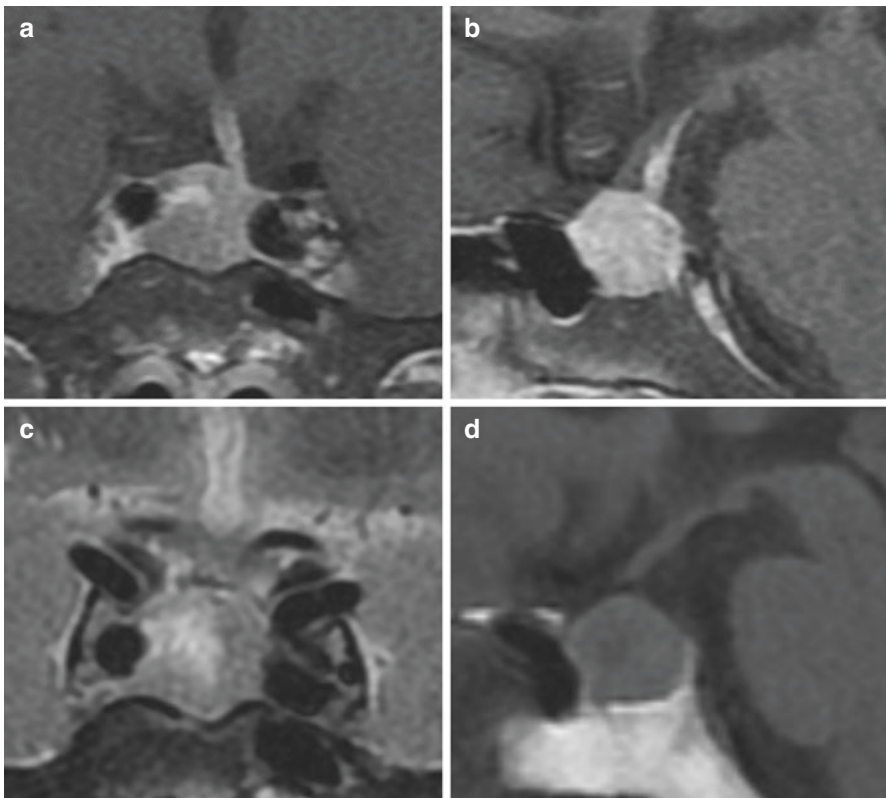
MRI appearance of a pituitary macroadenoma. (a, b) Coronal and sagittal post-contrast T1-weighted imaging shows the characteristic heterogenous enhancement of a pituitary macroadenoma. The right-sided lesion causes leftward deviation of the pituitary infundibulum. (c) T2-weighted coronal imaging shows heterogeneously hyperintense signal in the mass. (d) Pre-contrast T1-weighted sagittal imaging shows loss of the normal posterior pituitary bright spot
